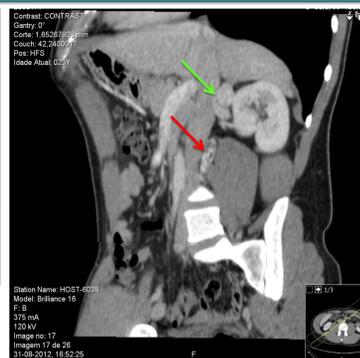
Abdominopelvic CT scan demonstrating the right adrenal pheochromocytoma (green arrow) and the right paraganglioma (red arrow).
